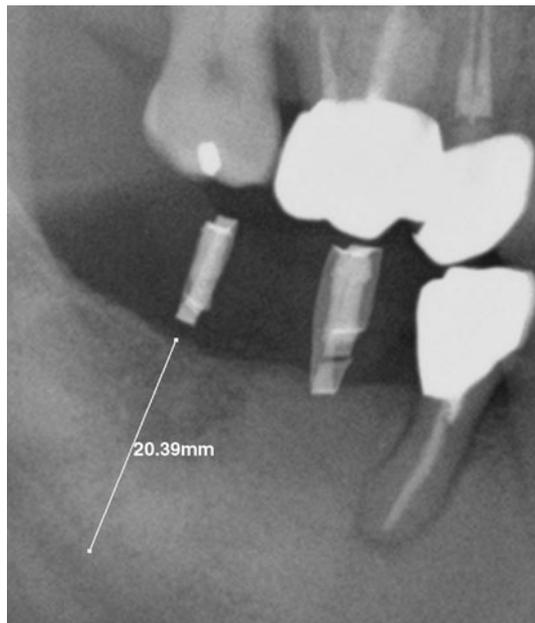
Measurement of linear distance on a panoramic radiograph
